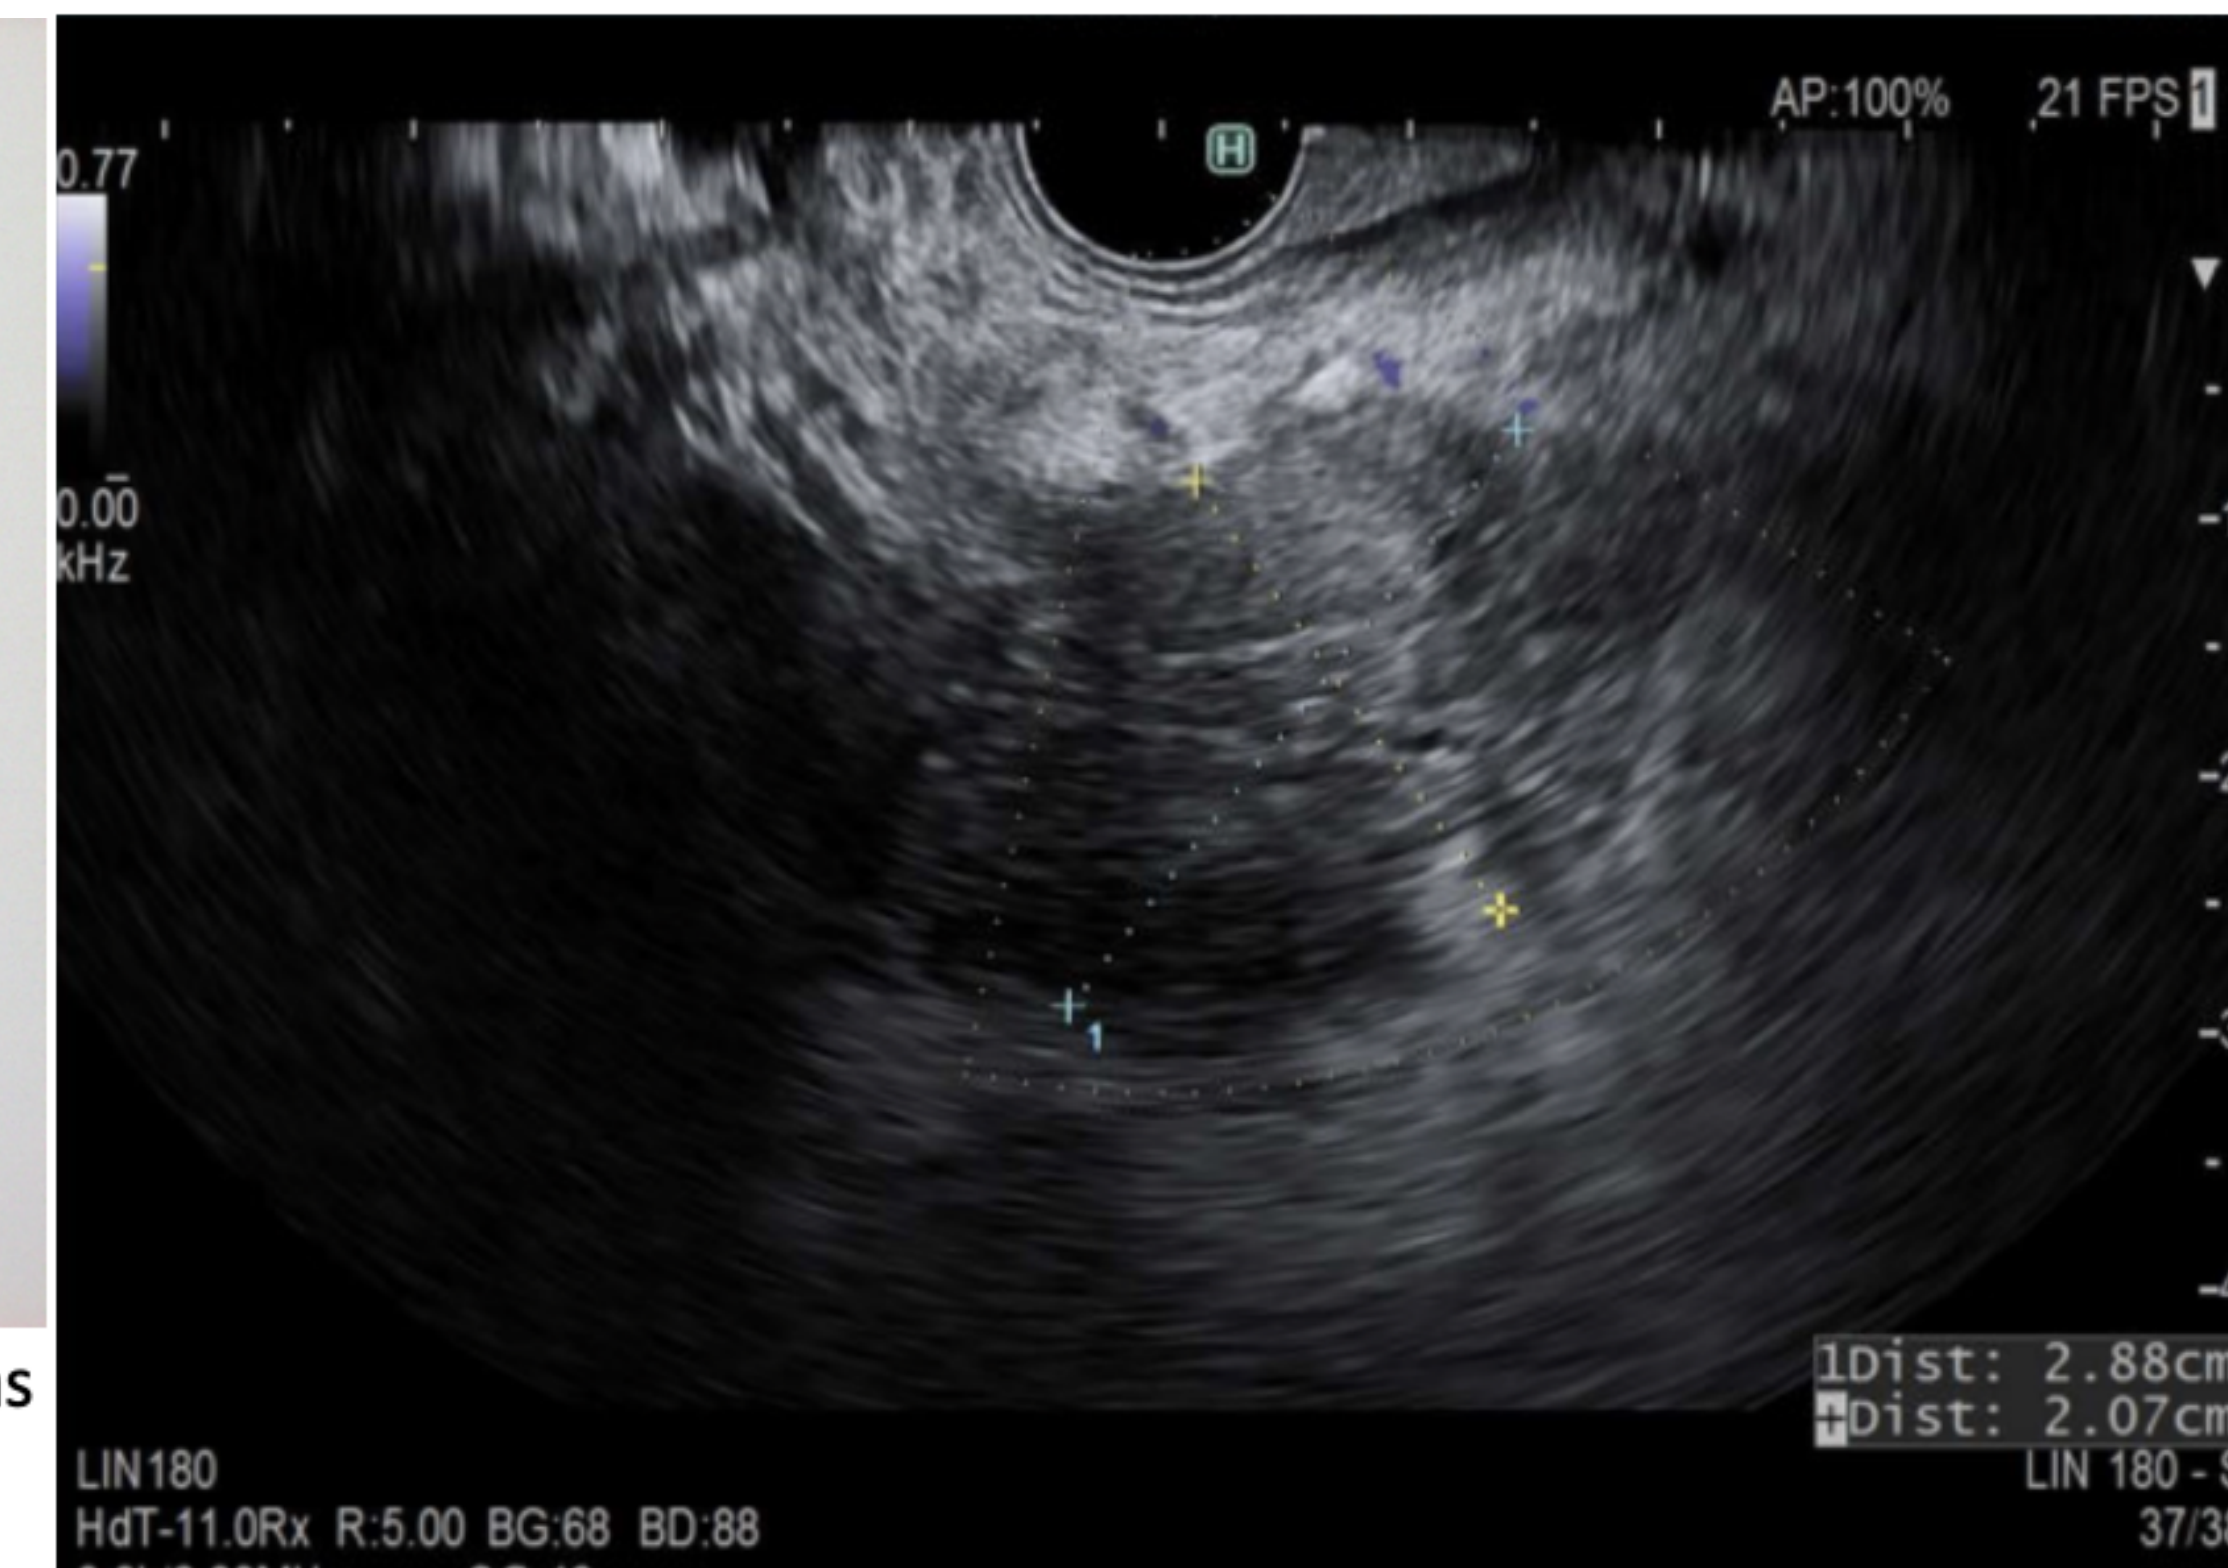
Pancreatic head mass on endoscopic ultrasound
